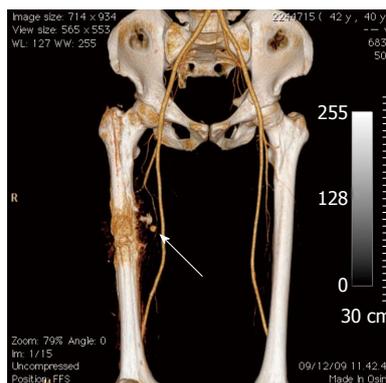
Computed tomography appearance of pseudoaneurysm. Computed tomographic angiogram showing pseudoaneurysm of profunda femoris artery (arrow).
